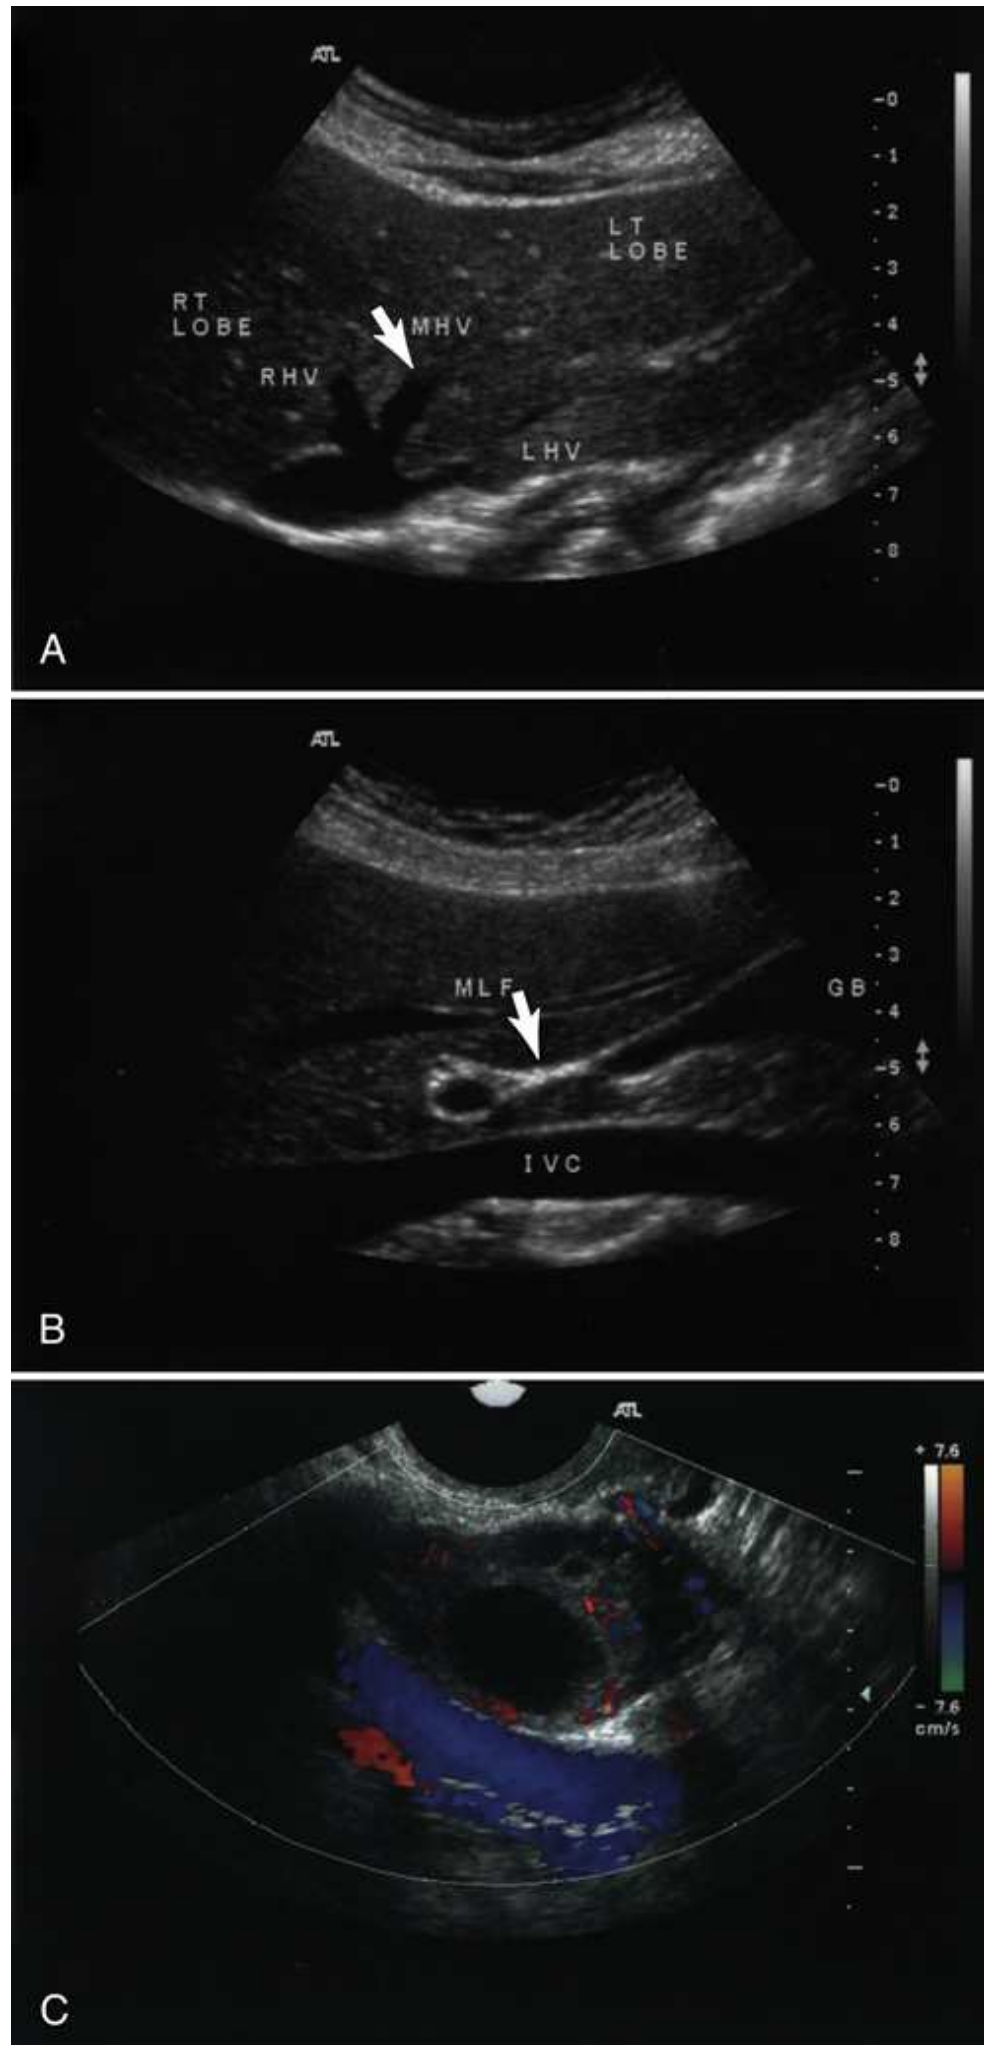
(A) Transverse sonogram of liver showing middle hepatic vein (*MHV*) dividing left and right hepatic lobes. (B) Sagittal image of main lobar fissure (*MLF*) and its relationship to gallbladder (*GB*). (C)
